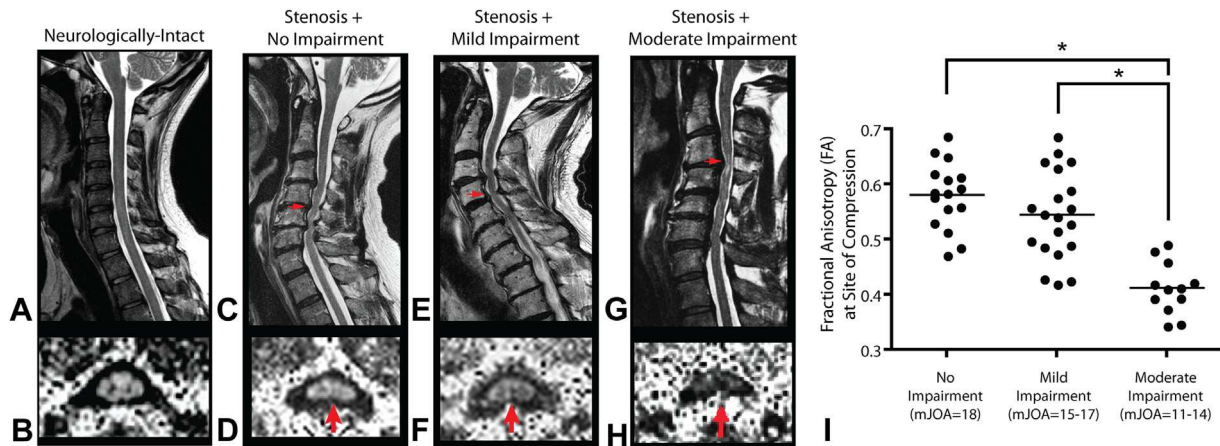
FA at the site of spinal cord compression. (A, C, E, G) Sagittal T2-weighted and (B, D, F, H) FA images of a neurologically intact (A, B) control subject, (B) showing high FA in spinal cord white matter, (C, D) a patient with cervical spondylosis without neurologic impairment (mJOA=18), (E, F) a patient with cervical spondylosis with mild impairment (mJOA=15), and (G, H) a patient with cervical spondylosis with moderate impairment (mJOA=12). Note that patients demonstrate a decreasing FA at the site of most severe compression with increasing neurologic impairment, suggestive of increasing microstructural damage. Note on axial images, posterior=top, anterior=bottom. (I) Comparison of FA at the site of compression between patients without neurologic impairment (mJOA=18), patients with mild impairment (mJOA=15–17), and patients with moderate impairment (mJOA=10–14). Results show a significant difference between patients with moderate impairment and those with mild or no impairment (analysis of variance, $p! .0001$; Tukey test, $p! .05$ for moderate vs. mild or no impairment). The arrows show region of spinal cord compression. $*p! .05$. mJOA, modified Japanese Orthopedic Association.
